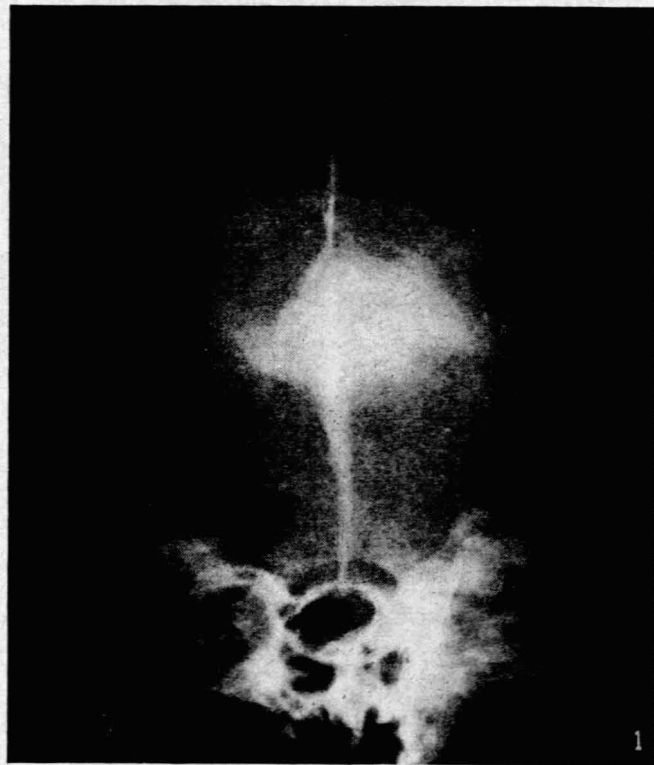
Radiograph of skull, showing calcification of the falx cerebri.
